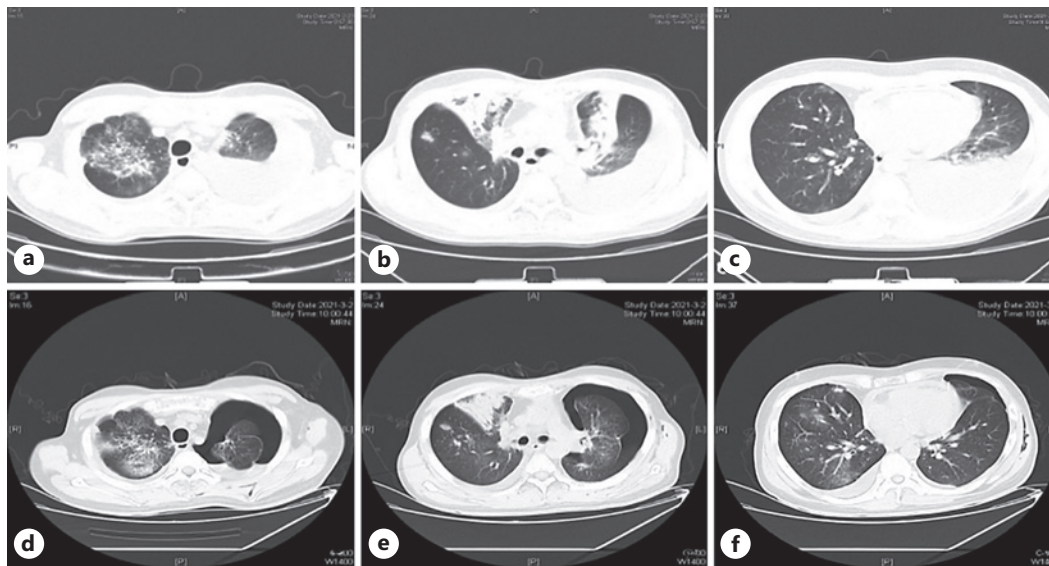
a–c Chest CT showing multiple lamellar hyperintensities with blurred margins in both lungs, nodular foci in the right lung, bronchial inflation signs in some of the lesions, bilateral pleural effusions. d–f Right lung lamellar hyperintensity shadow, a nodular shadow is more than before, partly with ground-glass change, left pleural effusion is reduced, and with artificial pneumothorax.
